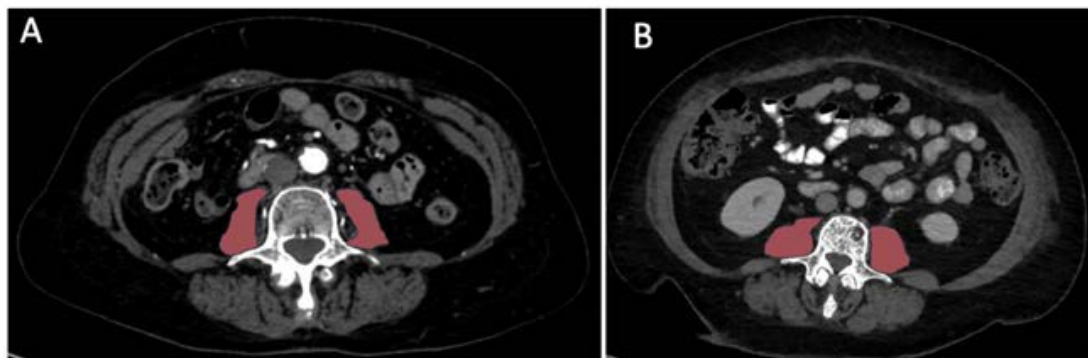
CTA assessment of psoas muscle cross-sectional area (CSA) at L3 level. *Highlighted: Bilateral psoas CSA*
